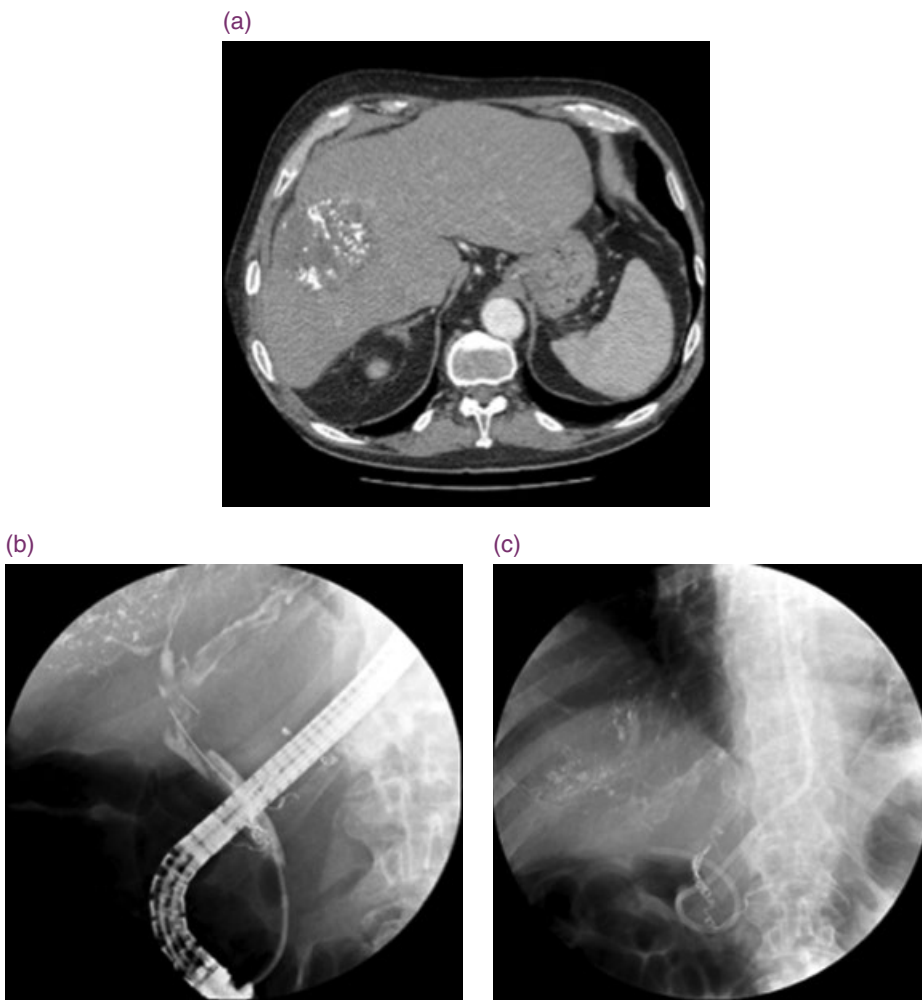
Hemobilia after transhepatic arterial chemoembolization (TACE). (a) Computed tomography showing the tumor treated by TACE. (b) Cholangiogram showing multiple filling defects inside the bile ducts (hemorrhage and blood clots). (c) In the presence of massive amounts of blood clots, a nasobiliary drain is an adequate initial decompression therapy. During subsequent endoscopic retrograde cholangiopancreatography, stenting may become necessary to enable bile flow.
